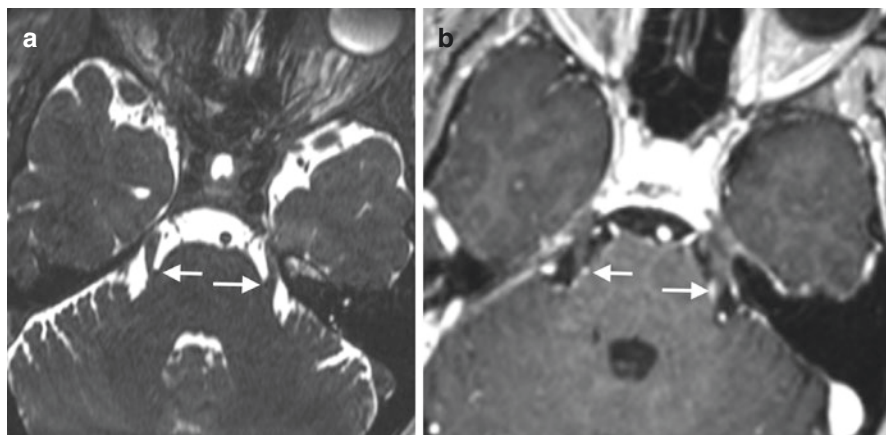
Axial T2-weighted SSFP image (a) and a contrast-enhanced T1-weighted turbo field echo (TFE) acquisition (b) reveal bilateral neurovascular contact at the trigeminal root entry zones (arrows)
